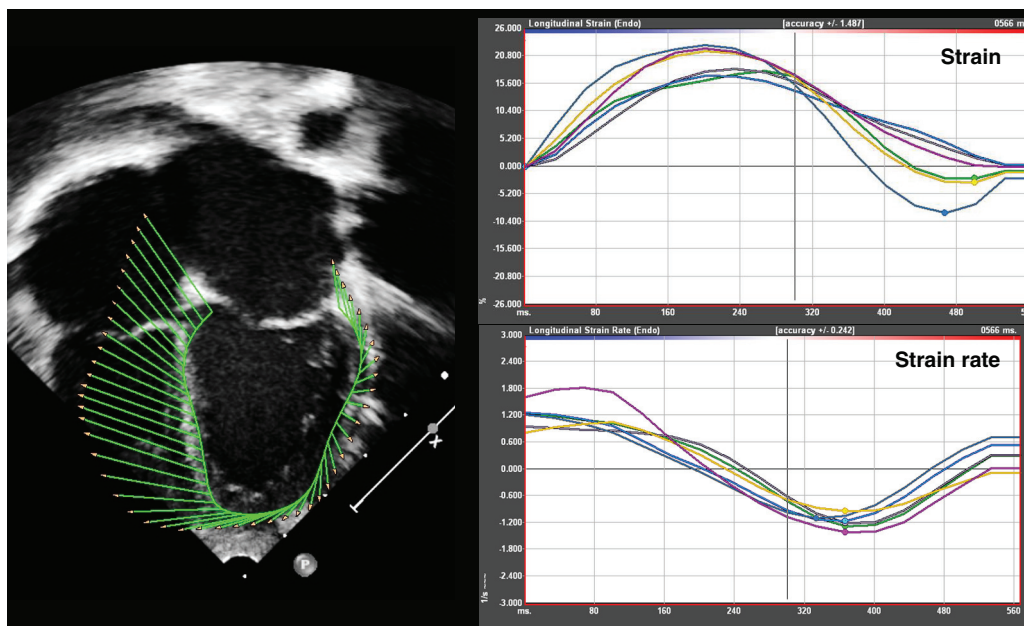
■ Speckle-tracking echocardiography. Left panel: Apical four-chamber view with velocity vector mapping of the left ventricle. Right upper panel: Longitudinal strain versus time curves in six segments of the left ventricular wall. Right lower panel: Longitudinal strain rate versus time curves in the same segments.
